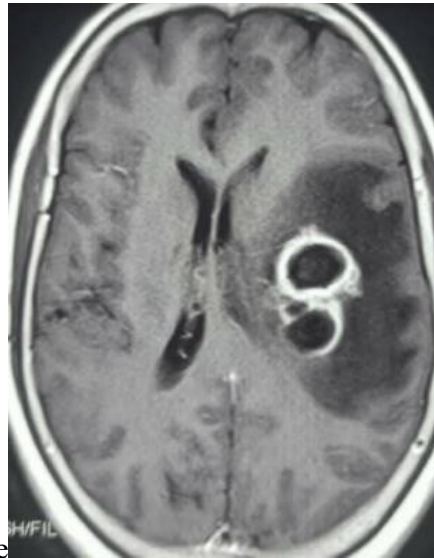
Cerebral abscess with CT Scan⁹
